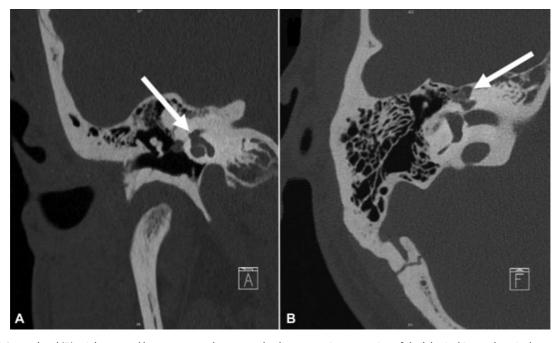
(A) Coronal and (B) axial temporal bone computed tomography demonstrating expansion of the labyrinthine and geniculate segments of the fallopian canal with honeycomb stippling (intralesional spindle-like calcifications) and a cochlear fistula.
